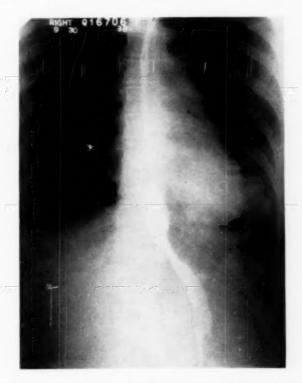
Case 10: F.J. X-ray film of chest September 30, 1938 showing left lower lobe partial atelectasis due to carcinoid type of adenomatous bronchial tumor obstructing two segments of the left lower lobe, Duration 18 years, alive and well 10½ years after left lower lobectomy. Same case as Figure 13.
